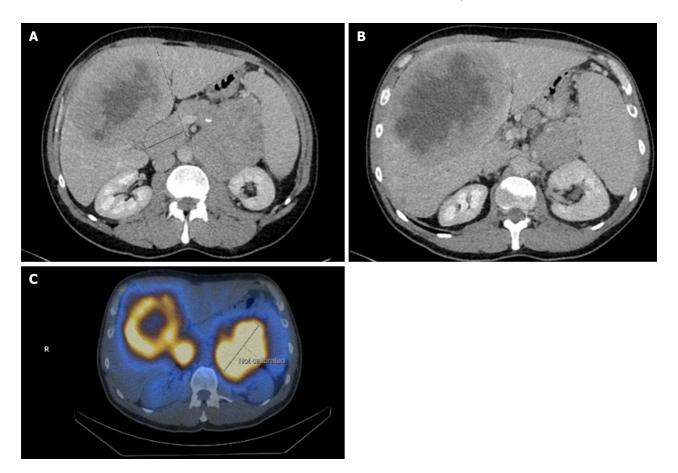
Initial CT-TAP confirmed 10 cm × 9.5 cm 1° mass in the pancreatic tail, extending diffusely into the pancreatic body. A and B: Evidence of metastasis – 15 cm necrotic mass in segment 8 of the liver (B); C: Increased Octreotide uptake is shown on the OctreoScan, confirming the presence of somatostatin receptor positivity.
